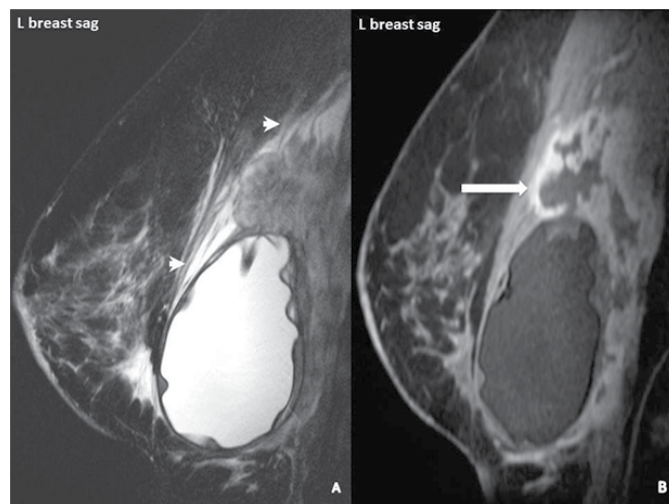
Left breast sagittal T2 fat-suppressed MRI image showing peritumoral edema (arrowheads) (A) and T1 post intravenous contrast administration (8 ml Gadovist®) subtracted image (B) shows an irregular, lobulated, peripherally enhancing mass posterosuperior to the left implant with invasion of the chest wall (arrow).
